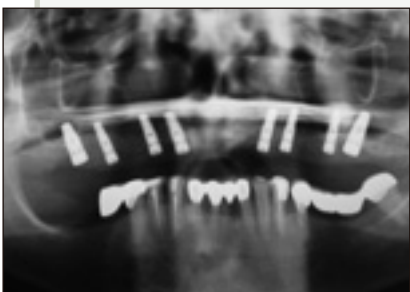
Panorax radiograph of 8 maxillary implants well spaced around the arch.
